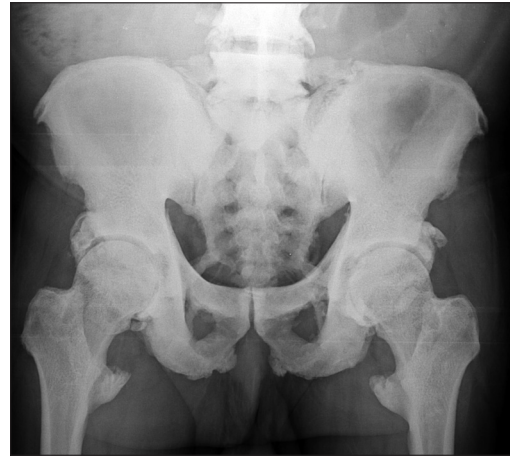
X-ray Pelvis AP view- reveals Osteosclerosis with ossification of sacrotuberous ligament, sacrospinous ligament, iliolumbar and lumbosacral ligaments and bony overgrowth at ligamentous attachment site.
